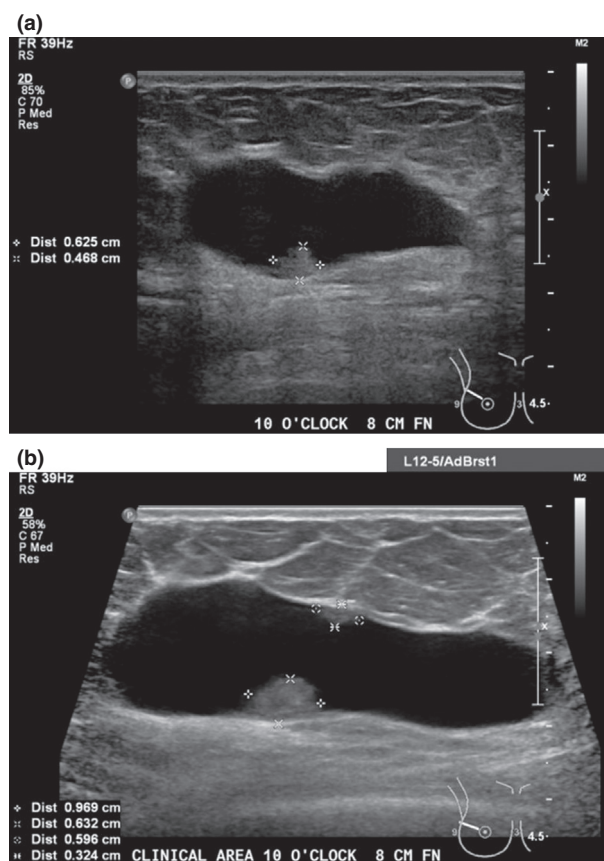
Ultrasound images taken in 2012 (a) and 2014 (b), demonstrating the increased size and additional nodules. Image courtesy of BreastScreen ACT.
